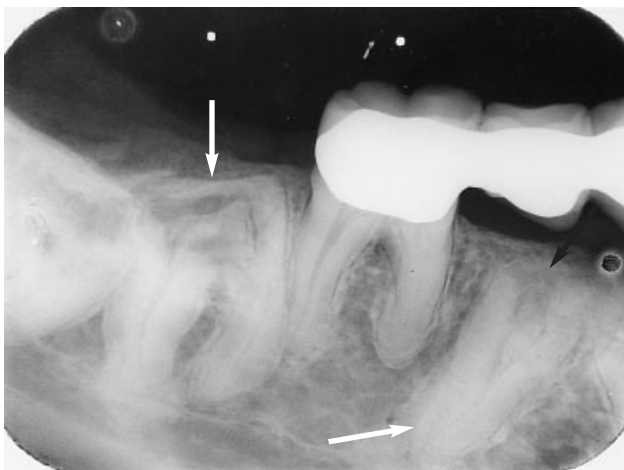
An intraoral radiograph from the brother demonstrating the presence of unerupted teeth (open arrows) affected by hypoplastic amelogenesis imperfecta, with characteristic extensive coronal resorption and probable intrapulpal calcification (closed arrow).
